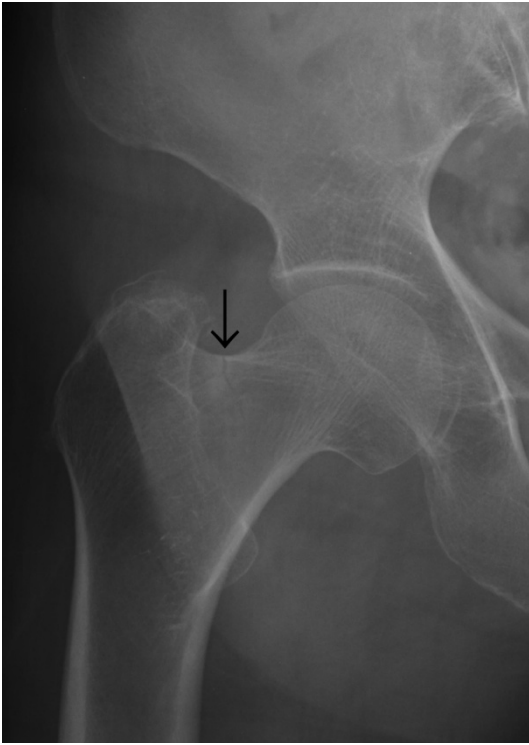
Initial radiograph shows a right femoral neck fracture with sclerotic superior cortex and an undisplaced linear pattern.
